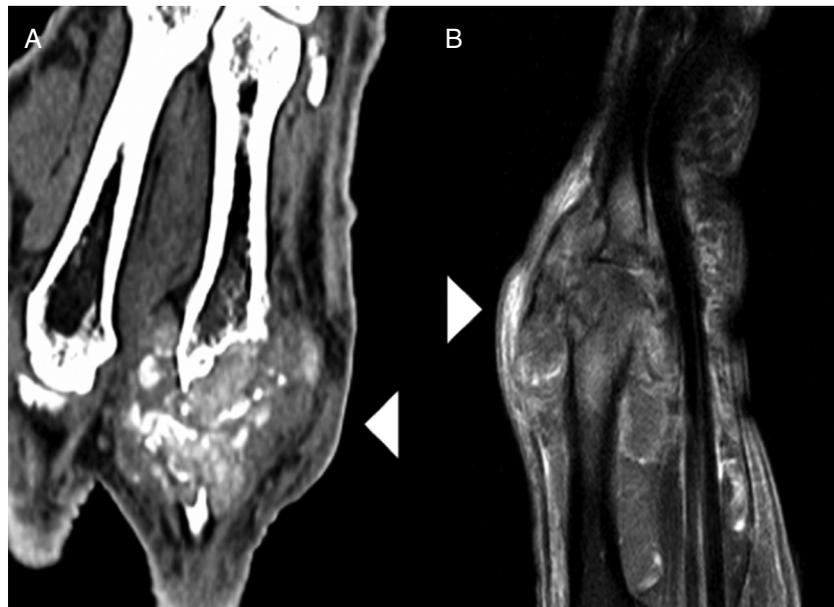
CT image (A) and MR (B). The tumor is of lobulated morphology, a diffuse component with calcified areas inside which eroded the bony surfaces of the metacarpophalangeal joint (white arrow heads).
